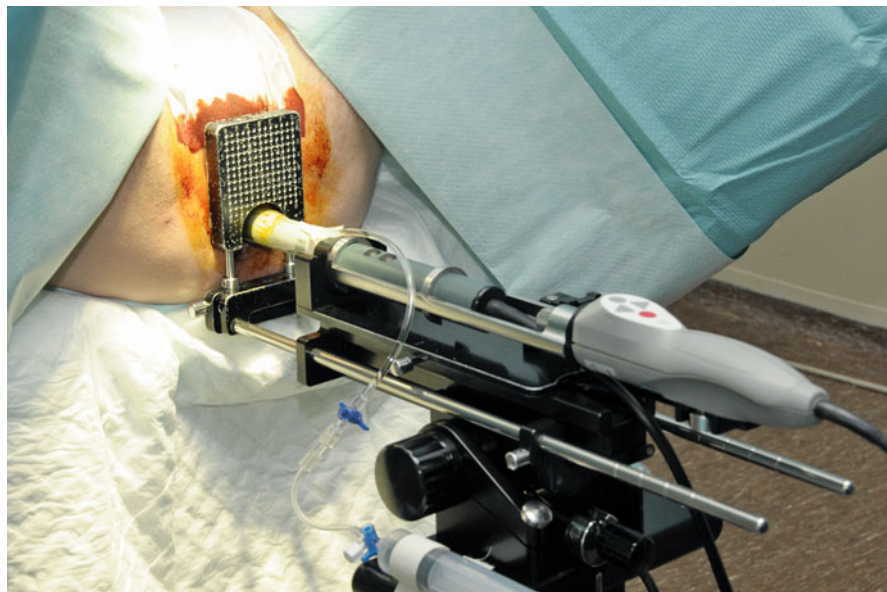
Support system with stepping unit, template, ultrasound system and probe with 3D capability
